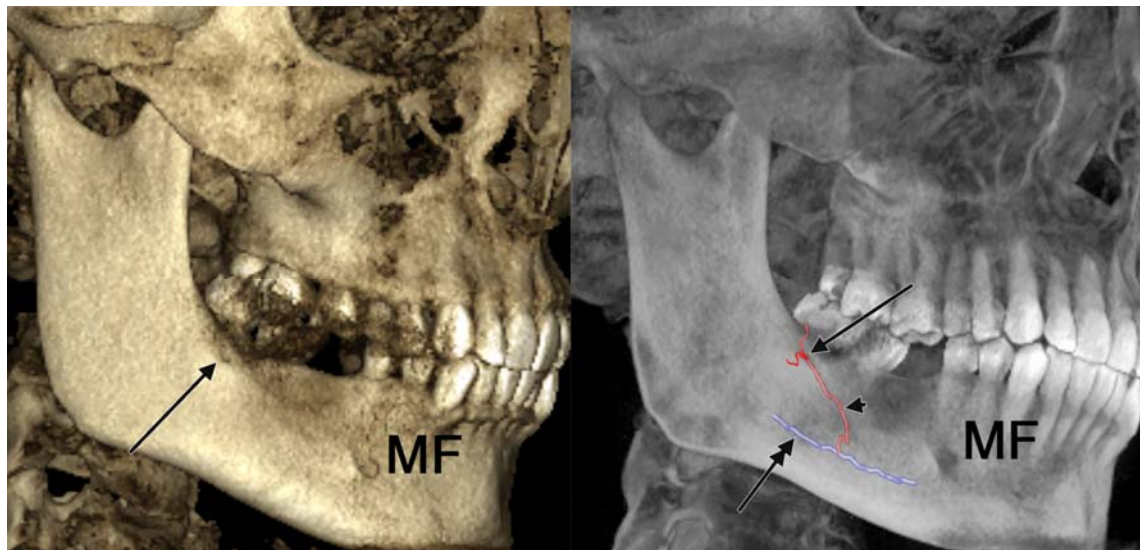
Three-dimensional renderisations of the right hemimandible, lateral views (left: Xray Shaded Filter, right: B&W Xray Filter, with reconstructions of canals). The arrows indicate the foramen of the oblique line which is connected through a canal (arrowhead) with the mandibular canal (double-headed arrow). MF: mental foramen.
